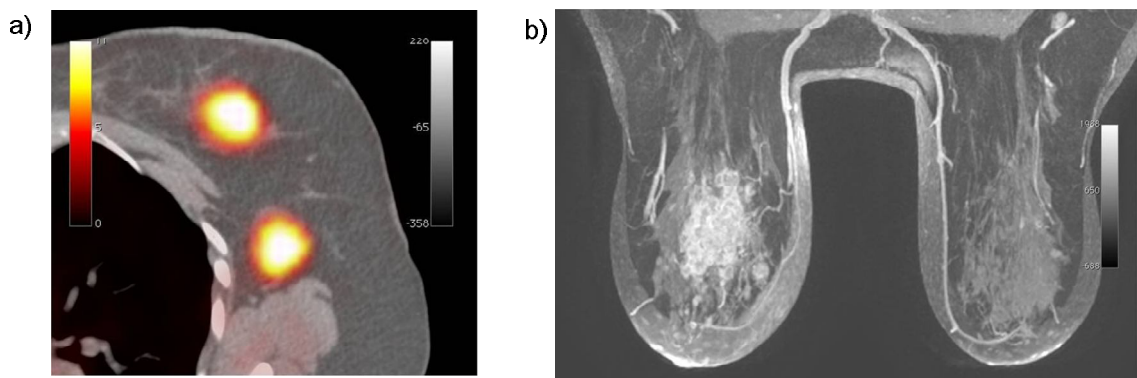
a) Whole-body PET/CT of the left breast and b) MRI of case 3
